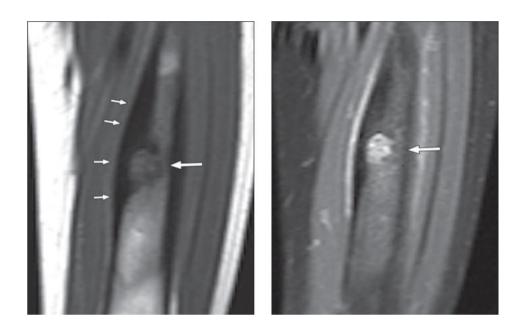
Femoral osteoid osteoma – Pre contrast T1-weighted image reveals hypointense nidus (large arrow) with fusiform cortical thickening (small arrows) overlying nidus. Post contrast T1-weighted image shows homogeneous nidus enhancement (arrow) (3).
